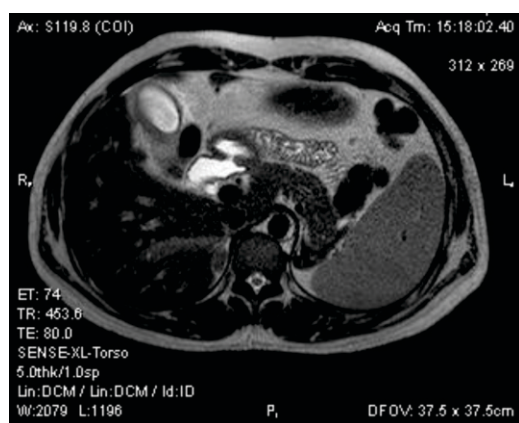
MRI abdomen revealed well defined round to oval T2W hyper intense lesion of size 1.2x2.2 cm showing significant contrast wash out s/o right adrenal adenoma . Left adrenal gland was WNL.(white arrow)
